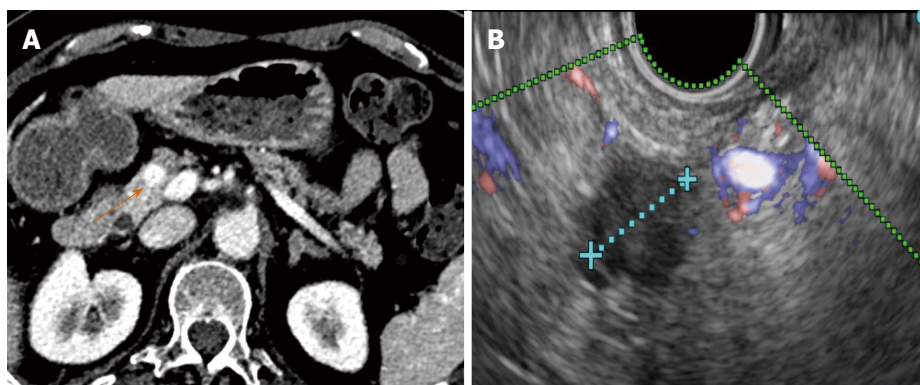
Ten millimeter pancreatic neuroendocrine tumour before radiofrequency ablation. Chromogranin at diagnosis: 239 ng/mL. A: The corresponding CT image (orange arrow); B: The corresponding Doppler endoscopic ultrasonography image.
